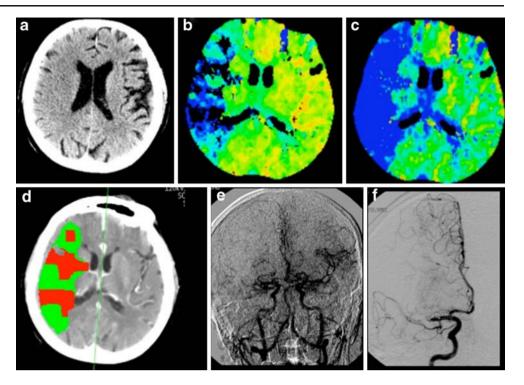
Sulcal effacement: On the unenhanced CT, there is sulcal effacement in the right hemisphere (a); this is associated with severe hypoperfusion as seen on the MTT maps (b, c). The penumbra map shows inhomogenous perfusion (d); the angiogram shows occlusion with hypovascularization (e) on the parenchymography overview due to M1 occlusion (f)
